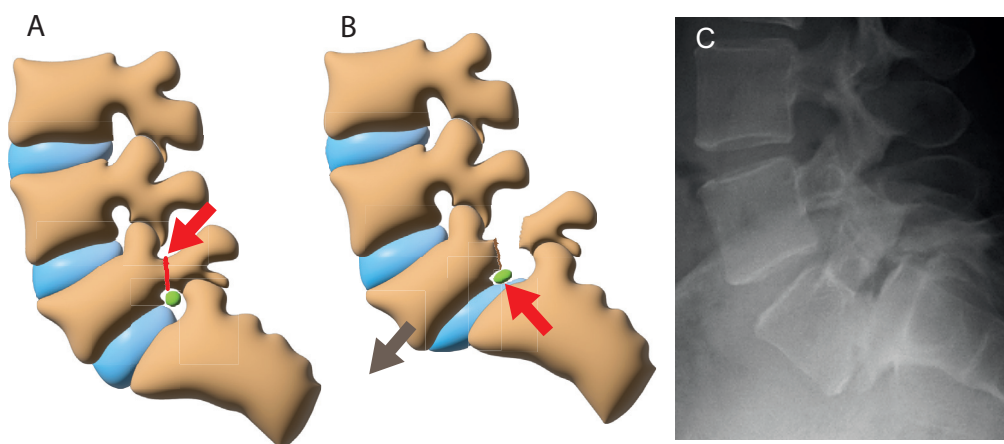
A. Spondylolysis due to fractured pars interarticularis B. resulting in isthmic spondylolisthesis (IS) causing foraminal compression of the exiting nerve root (green). C. A radiograph showing L5 spondylolysis and spondylolisthesis.
